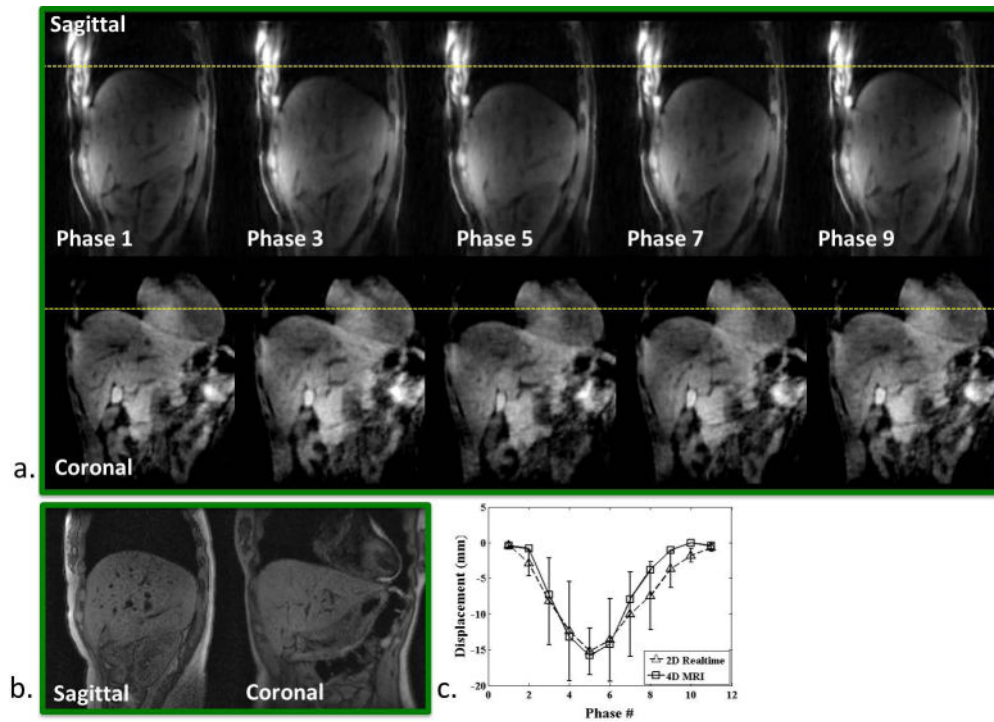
Healthy volunteer. a) Phase-resolved sagittal and coronal images (phase 1, 3, ..., 9) reformatted from the 4D MRI image series throughout the entire respiratory cycle. Dashed lines are drawn for better visualization of organ motion at each respiratory phase. b) A single frame of the corresponding real-time 2D-MRI image series. c) Measured SI displacement series, comparing between 4D-MRI and real-time 2D-MRI at each respiratory phase.
